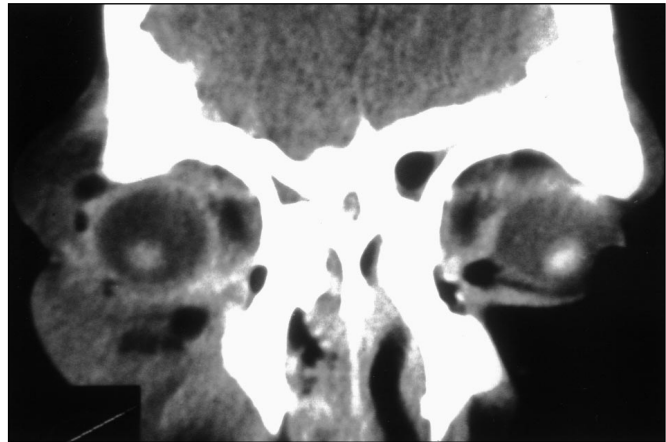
CT scan examination of the first patient: fullness is seen in the right inferior orbit.
